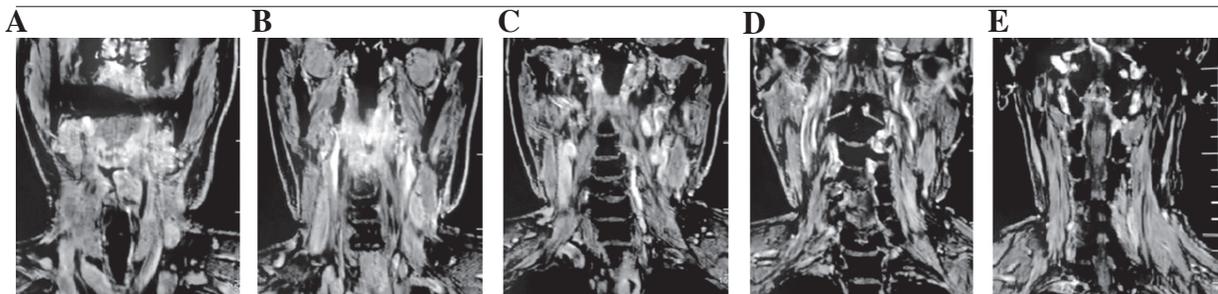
Neck MRI without contrast (A-E) showed post-subtotal laryngectomy changes, with marked thickening of the laryngeal soft tissue
